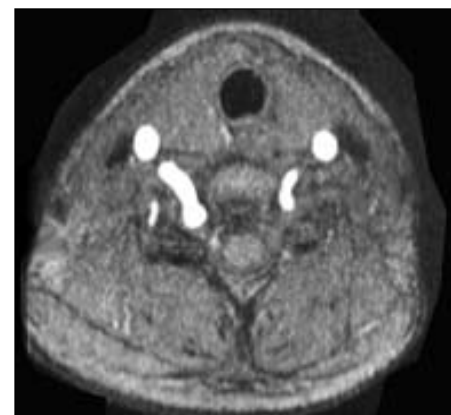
Bright blood axial MR image reveals that neural foraminal widening was due to vertebral artery tortuosity, and vertebral artery loop formation is compressing the C₇ root in the intervertebral foramen
